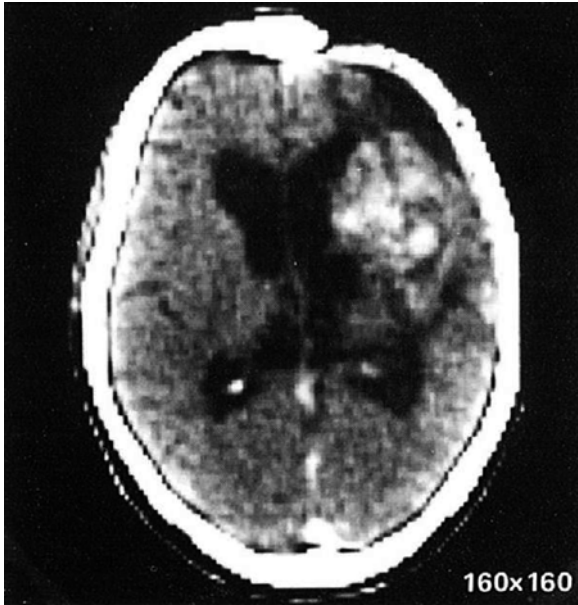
Early brain image from a CT head scanner. Reconstruction performed on a 160^2 matrix
